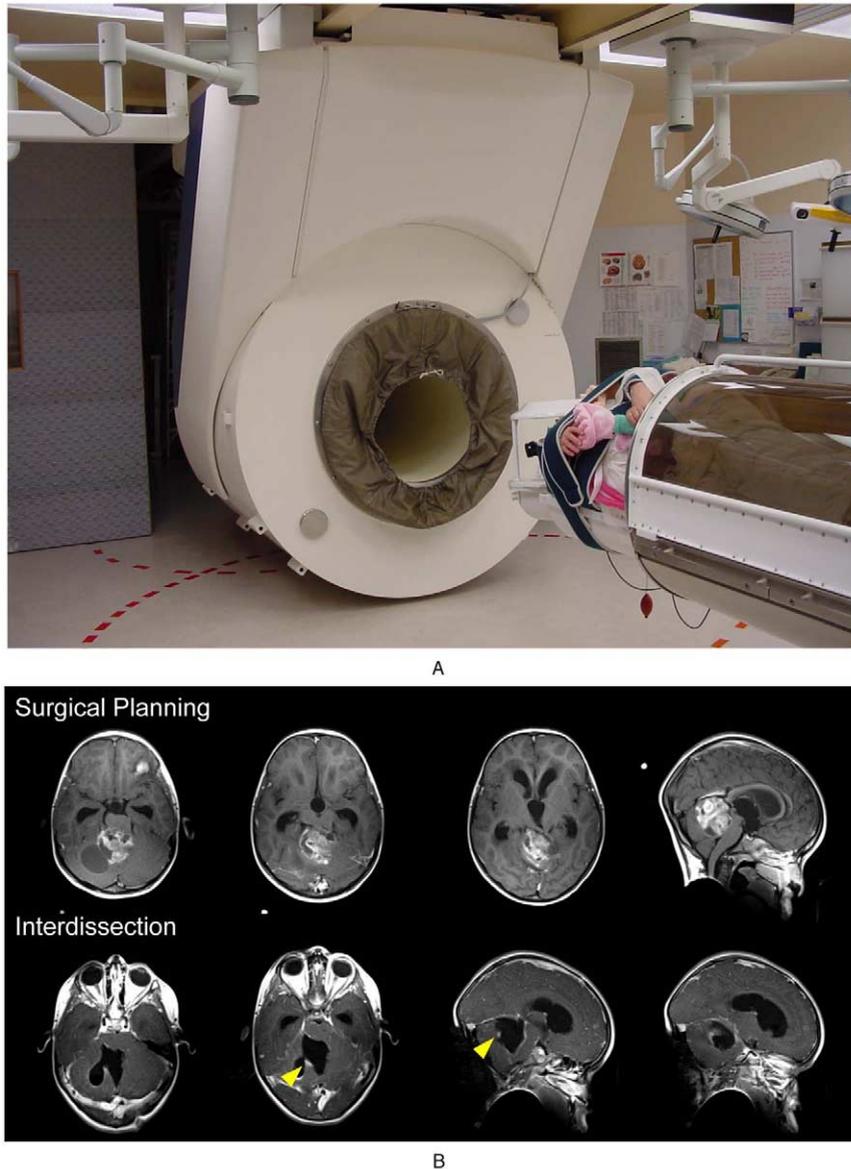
(A) Operating room equipped with a ceiling-mounted 1.5-T intraoperative magnetic resonance imaging system and surgical navigation system. (B) The interdissection (intraoperative) image shows a tumor that is cryptic to the microsurgeon, facilitating the complete removal necessary for cure.
